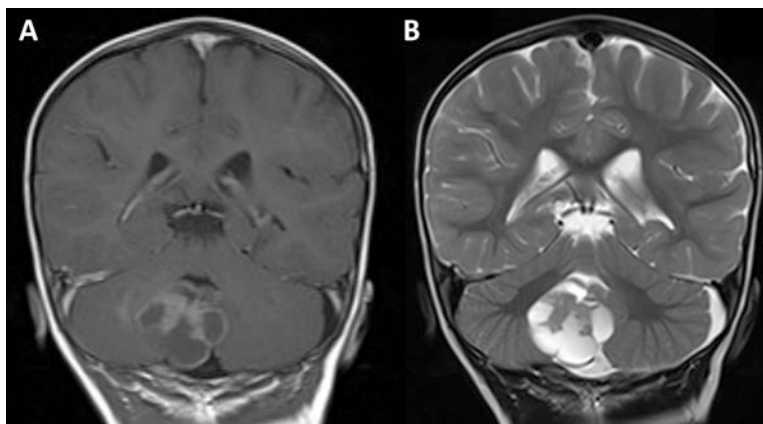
Seventeen month male with a 3.5 cm atypical teratoid/rhabdoid tumor, localized to the right cerebellar hemisphere with a central solid component and several cystic loculations. (a) T1 post-gadolinium. (b) T2-weighted image
